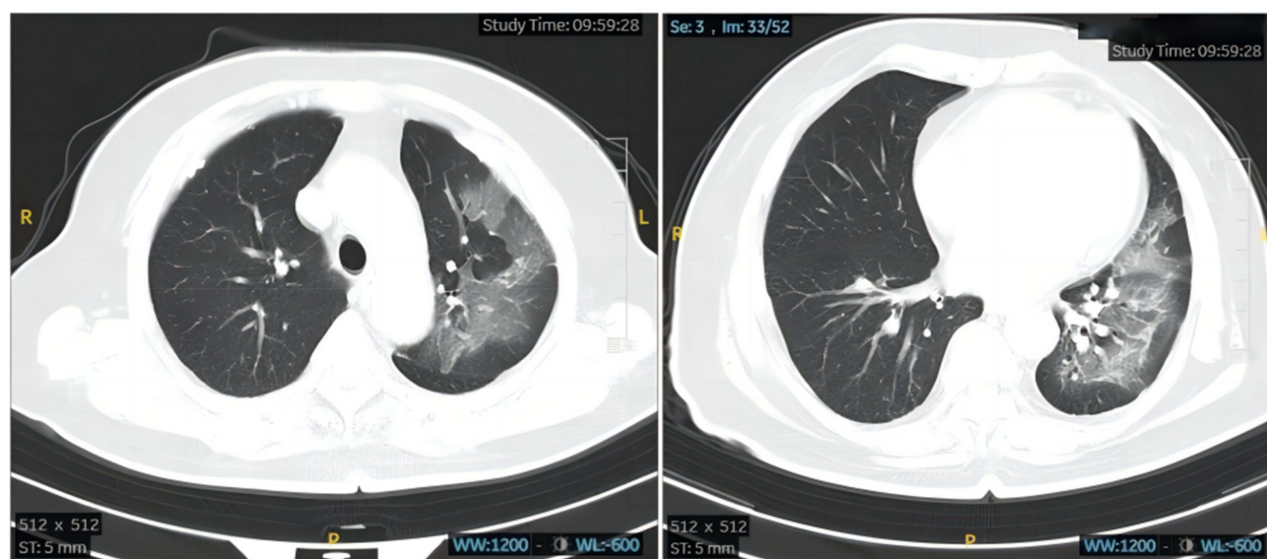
Chest computed tomography (CT) of the feverish patient.
